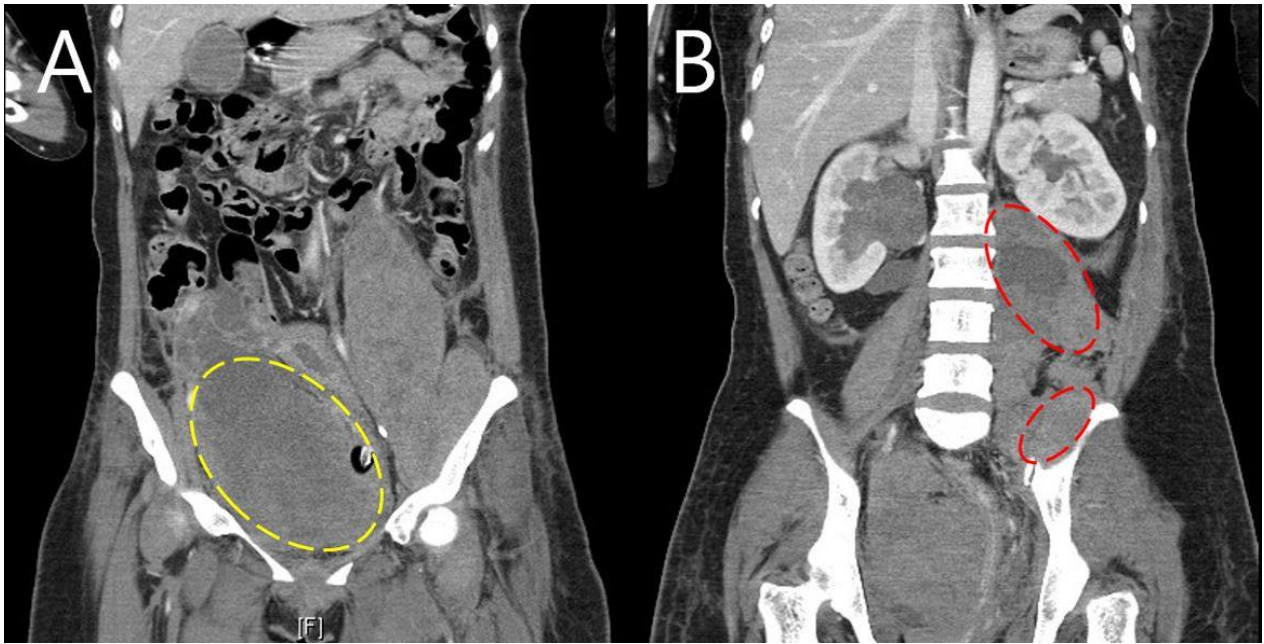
Contrast-enhanced abdomen-pelvis CT reveals a huge pelvic hematoma(yellow circle) and left iliopsoas muscle hematoma(red circle).
